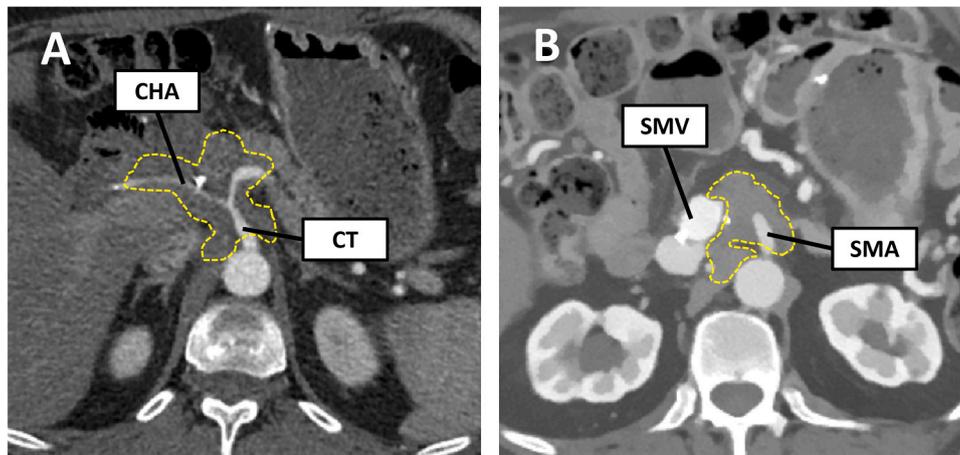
Recurrence of PDAC. Two cases of local recurrence of PDAC (dashed lines), in (A) encasing the celiac trunk (CT) and common hepatic artery (CHA), and in (B) encasing the superior mesenteric artery (SMA) and invading the superior mesenteric vein (SMV) with a teardrop sign.
